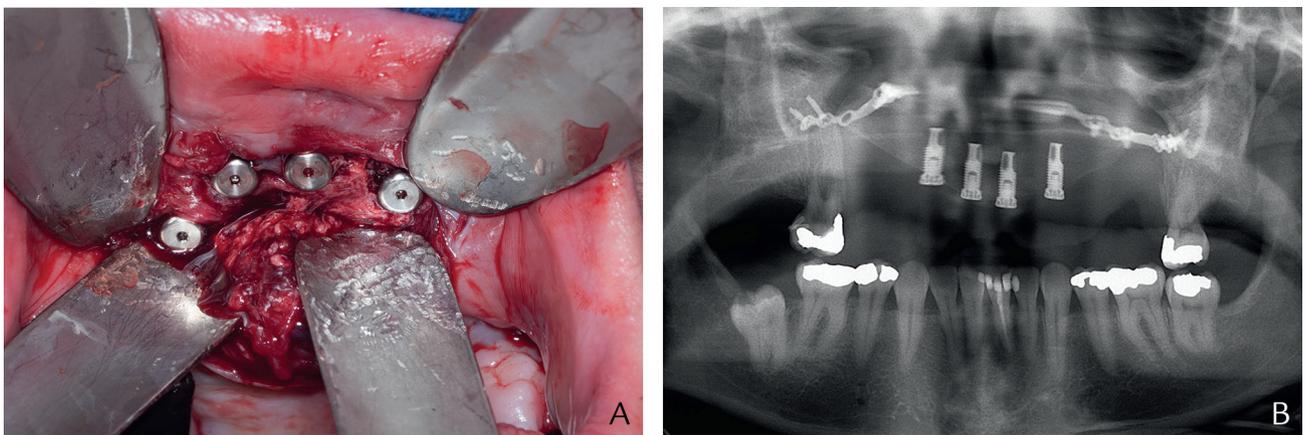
A, Placement of 4 dental implants in scapular graft. B, Panoramic radiograph indicating interim treatment situation.
